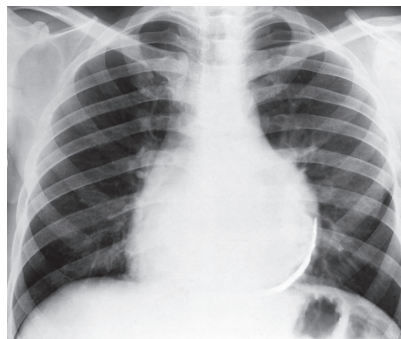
Frontal X-ray. Adhesive constrictive pericarditis with calcification
